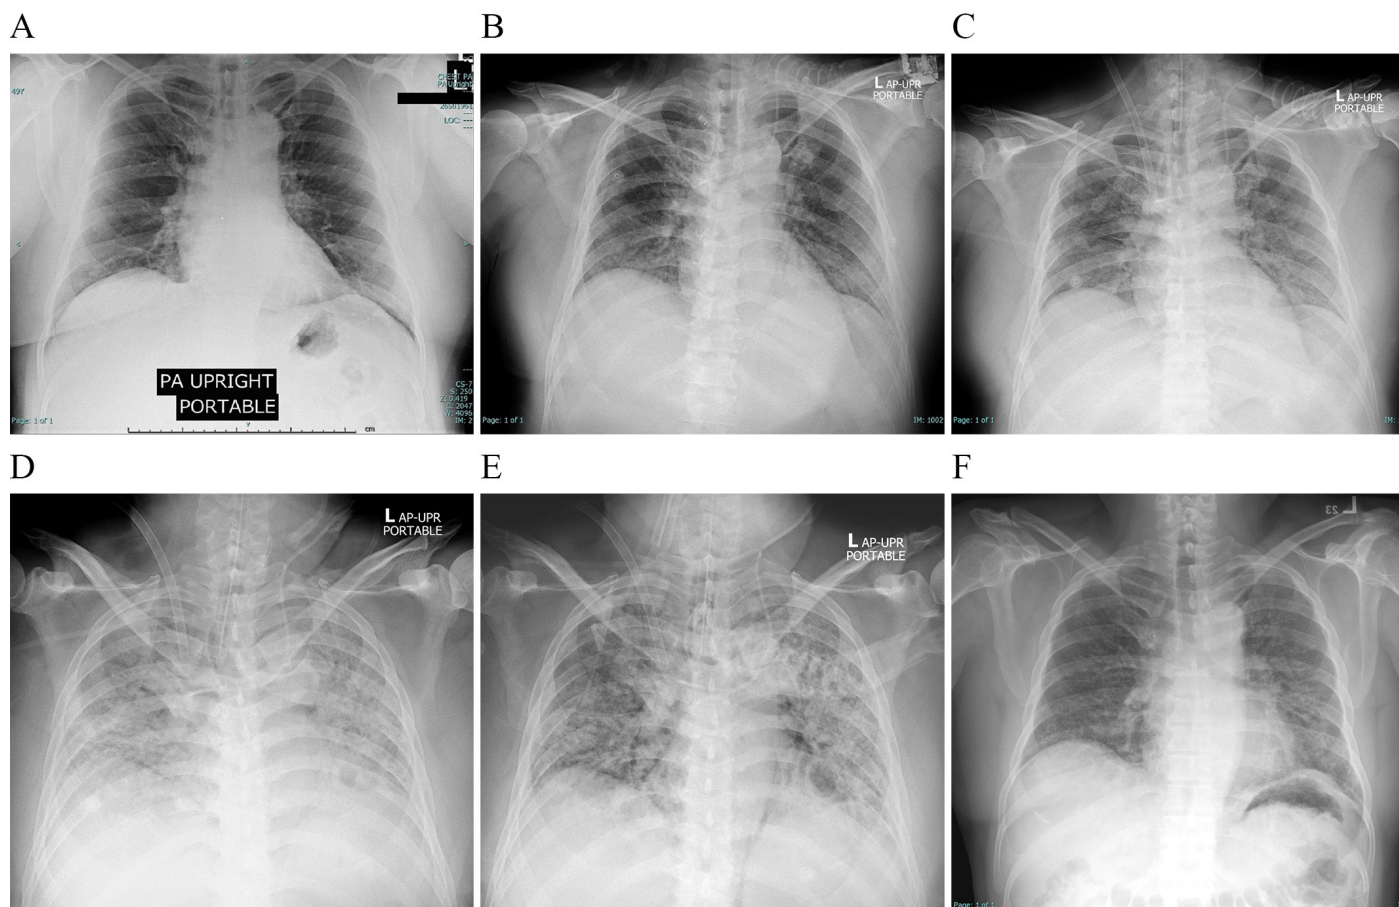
Chest radiographs of the patient (A) upon admission to another hospital at the onset of his symptoms; (B) upon admission to our intensive care unit; (C) after cannulation of V-V ECMO; (D) after 44 days of V-V ECMO, before prone positioning; (E) after 51 days of V-V ECMO, after five sessions of prone positioning; (F) at the follow-up visit one year after hospital discharge
